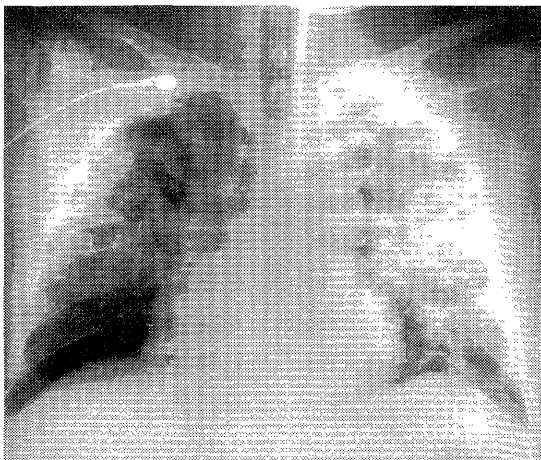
Two days after admission, chest X-ray film revealed infiltrative shadows in both lung fields.
